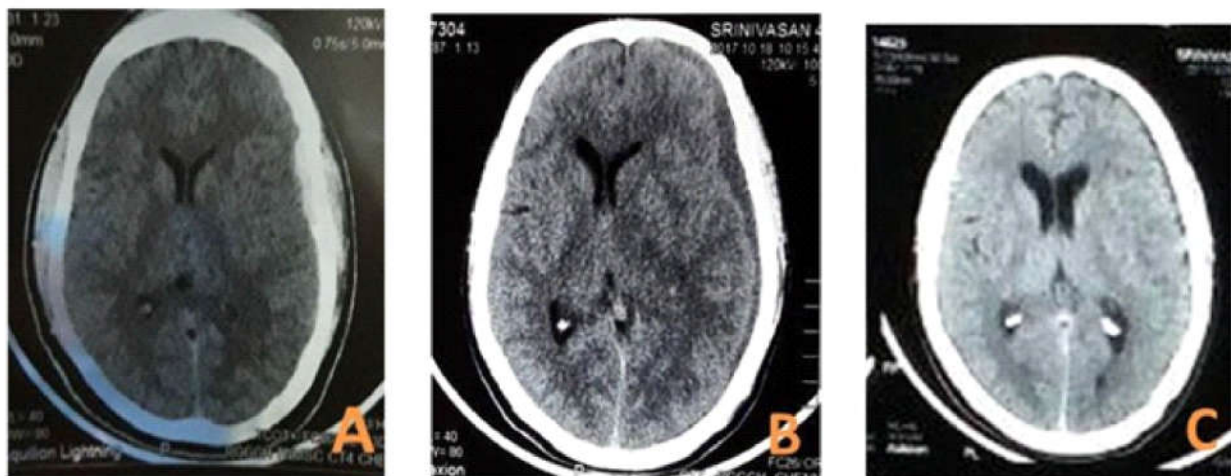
Case 1. CT scans of 45 year old male with history of RTA. A: on admission. B: on day 14. C: post burrhole evacuation.
